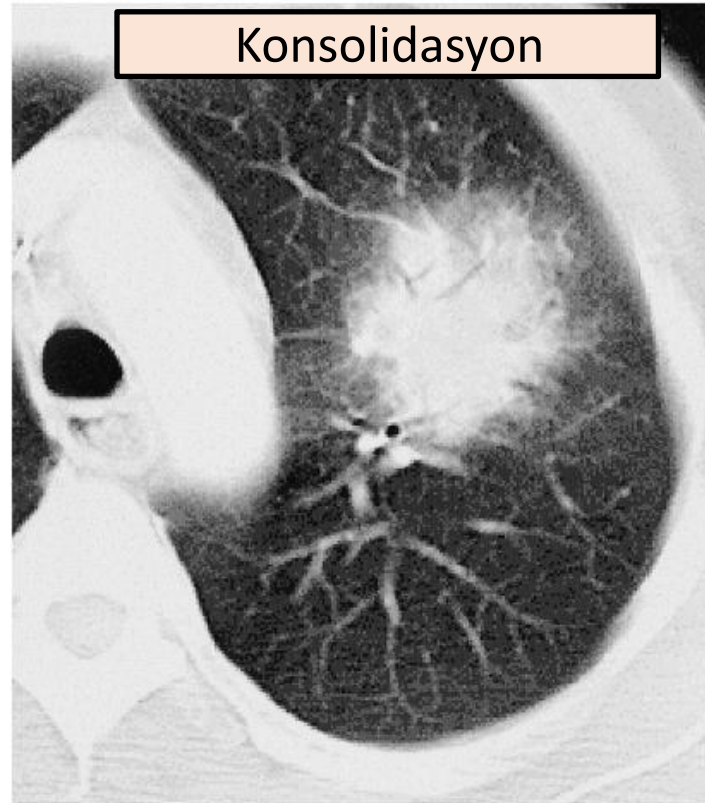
Low specific CT image. A new CT scan was performed 4 days later (day 4). It showed an increase of the left-sided aspergillary mass with a partial loss of peripheral ground glass attenuation.
